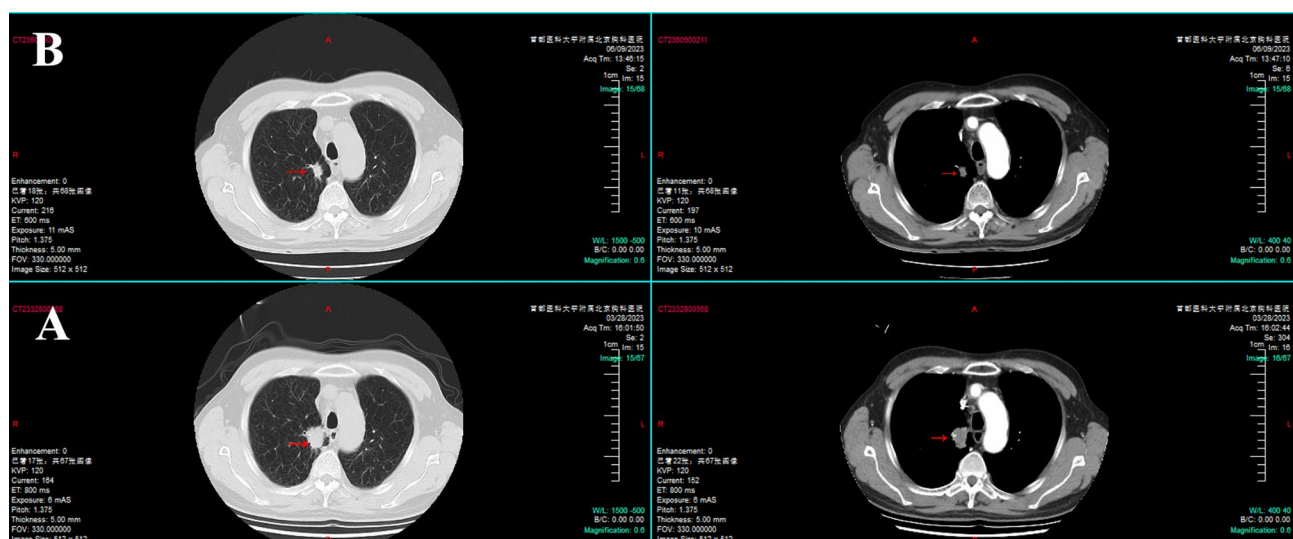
Radiologic response to neoadjuvant pralsetinib. Computed tomography (CT) imaging of chest before and after neoadjuvant pralsetinib treatment is shown. (A) A baseline CT of the chest before pralsetinib initiation revealed a left lung mass measuring 2.8 cm (red arrow). (B) A follow-up CT of the chest after two months of pralsetinib showed disease regression to 1.7 cm in the same mass (red arrow). This was classified as partial response by RECIST v1.1 per investigator assessment. RECIST, Response Evaluation Criteria in Solid Tumors
